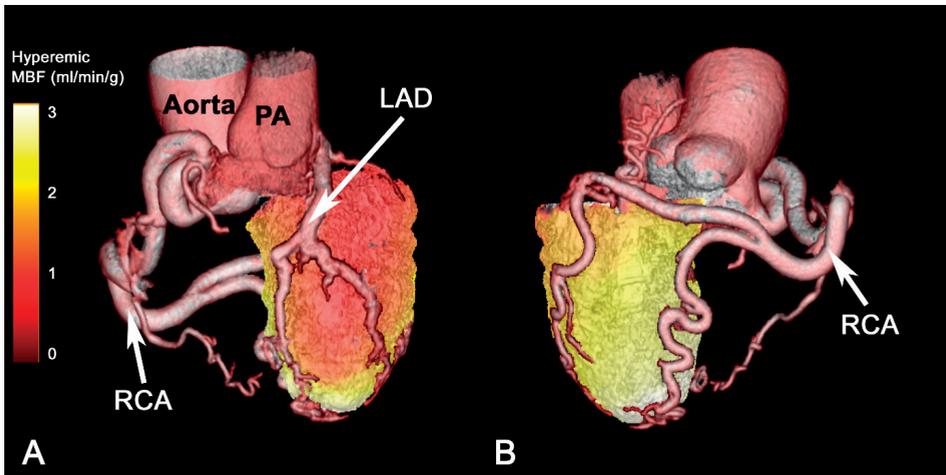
Fused CCTA/PET-MPI including quantitative hyperemic myocardial blood flow (MBF) of patient no. 1 with Bland-White-Garland syndrome (i.e. ALCAPA: anomalous left anterior descending artery origin from the pulmonary artery). On panel A impaired hyperemic MBF in the territory of the anomalous vessel (i.e. LAD) perfusion can be seen compared to normal hyperemic MBF of the non-anomalous vessel perfusion territory of the right coronary artery (RCA) on panel B. MBF = Myocardial blood flow; PA = Pulmonary artery; LAD = Left anterior descending artery; RCA = Right coronary artery; CCTA = Coronary computed tomography angiography; PET-MPI = Positron emission tomography myocardial perfusion imaging
